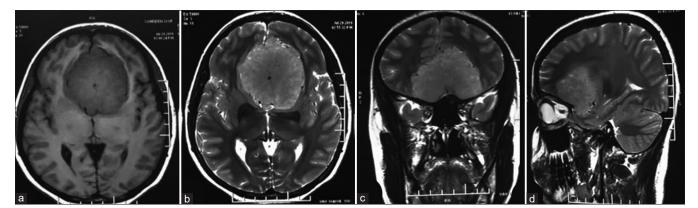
The magnetic resonance imaging appearance of the lesion. (a) Axial T1 weighted images showing a well-defined extra-axial mass arising from planum sphenoidale. (b) Axial T2 weighted images showing a well-defined extra-axial mass arising from planum sphenoidale compressing the bifrontal and capsule-ganglionic regions. (c and d) T2 coronal and sagittal sections of the lesion
